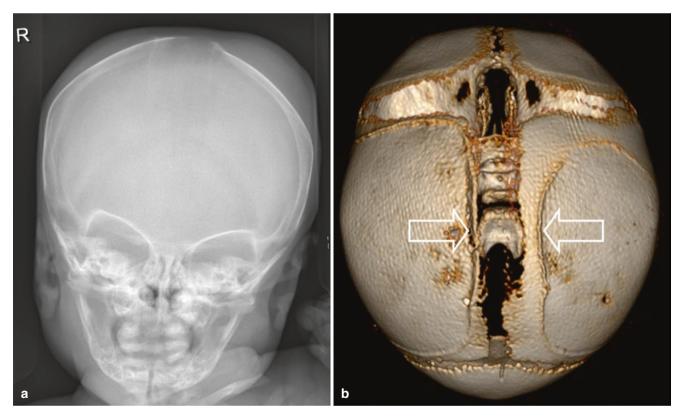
Neonate with a bilateral swelling. (a) Skull radiograph shows bilateral soft tissue swellings. (b) 3D CT at the age of 6 weeks shows calcified ridges along the edges of the cephalhaematomas (arrows)
